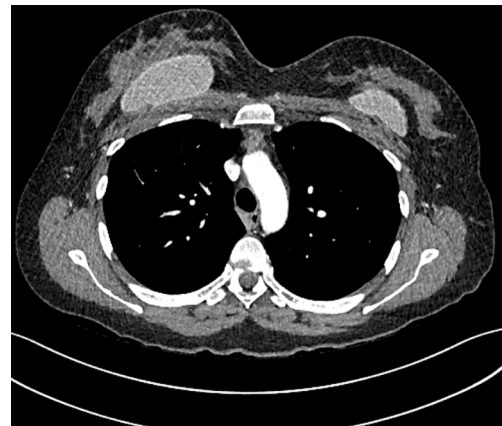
CT of a 38-year-old lady showing a 1.9 cm prominence of thymic tissue. CT, computed tomography.
